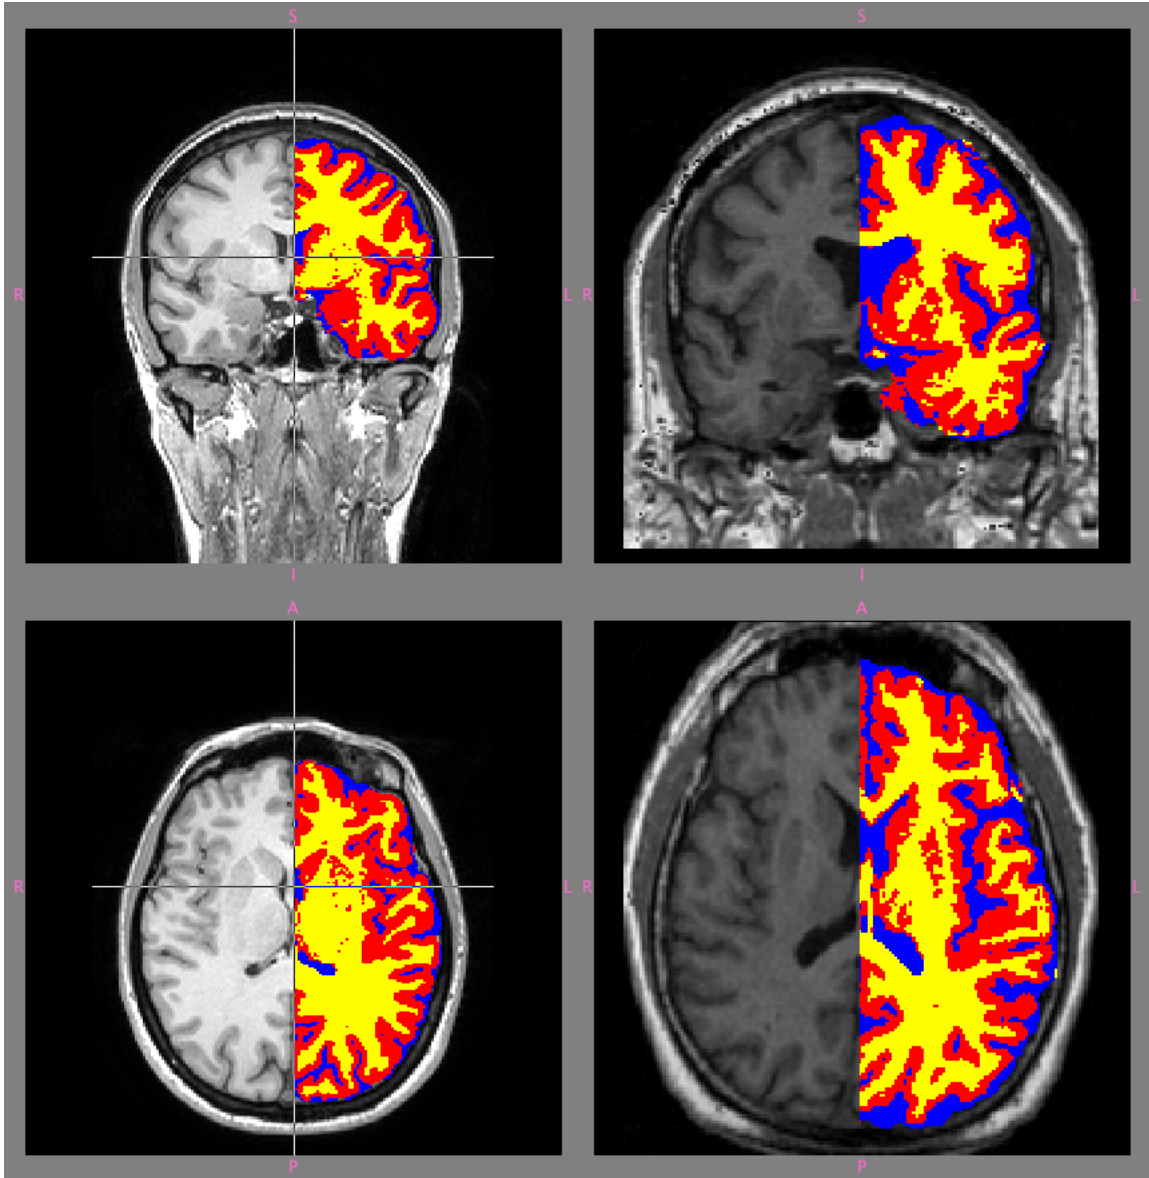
Image segments over-layed on T1 MRI in subject space.
